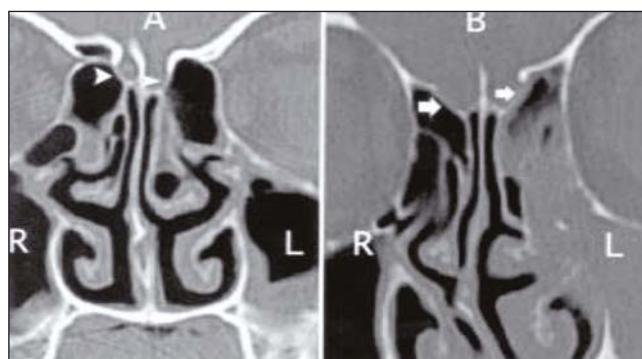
Coronal sinus CT scan showing A) lateral lamella (arrow heads)
